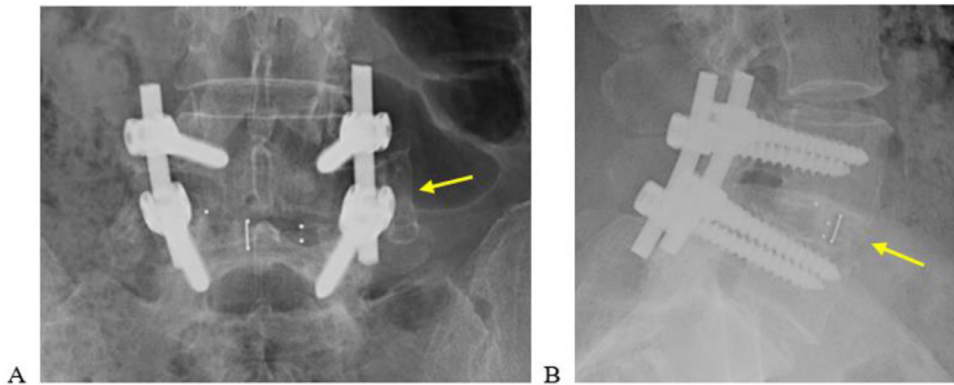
X-ray: (Left) Posterior fusion. (Right) Anterior fusion.
